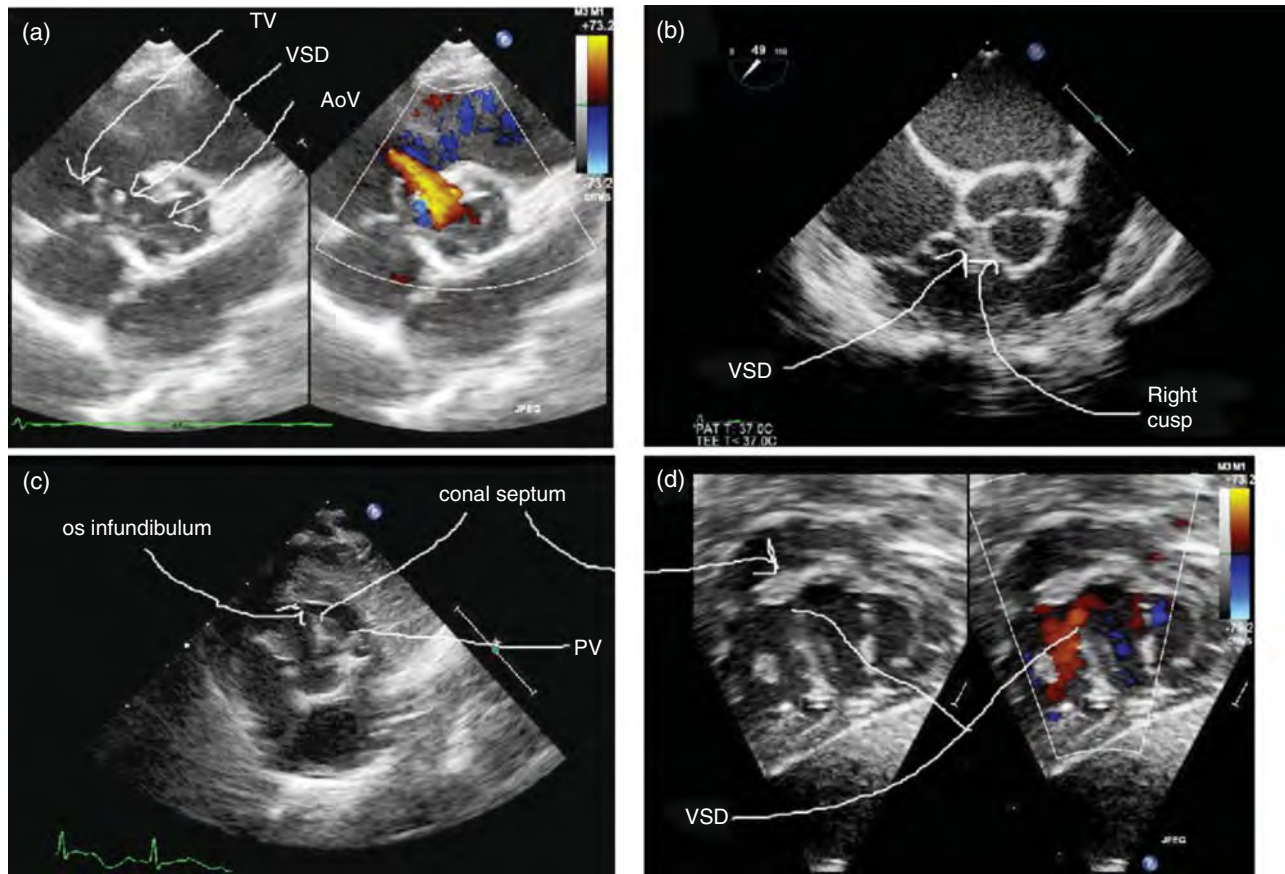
Conoventricular defects: (a) parasternal short-axis image without and with color showing the defect location between the aortic (AoV) and tricuspid valves (TV) without conal septal malalignment; (b) transesophageal view showing the right aortic cusp in the defect; (c) parasternal short-axis image showing anterior malalignment of the conal septum, narrowed os infundibulum, and small pulmonary annulus (PV) as seen in tetralogy of Fallot; and (d) subcostal sagittal image without and with color showing anterior malalignment of the conal septum.
